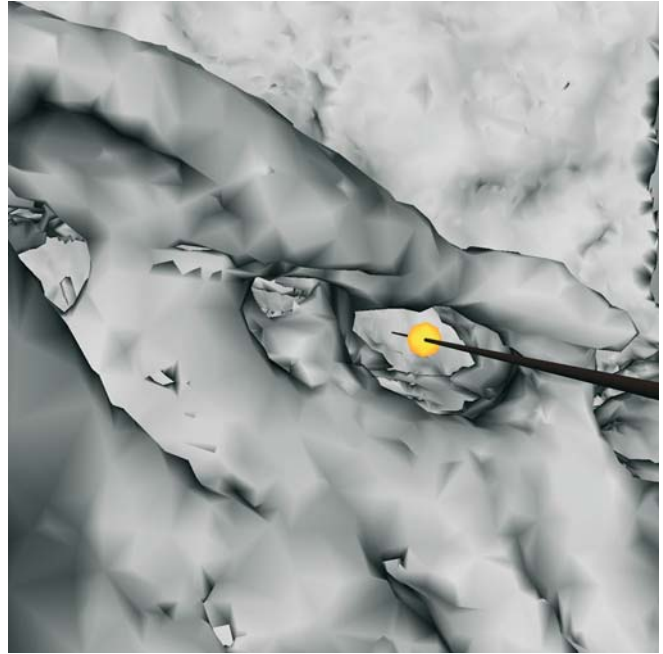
Nasion. Paramedian view left (3-D CT, patient K.C.)
